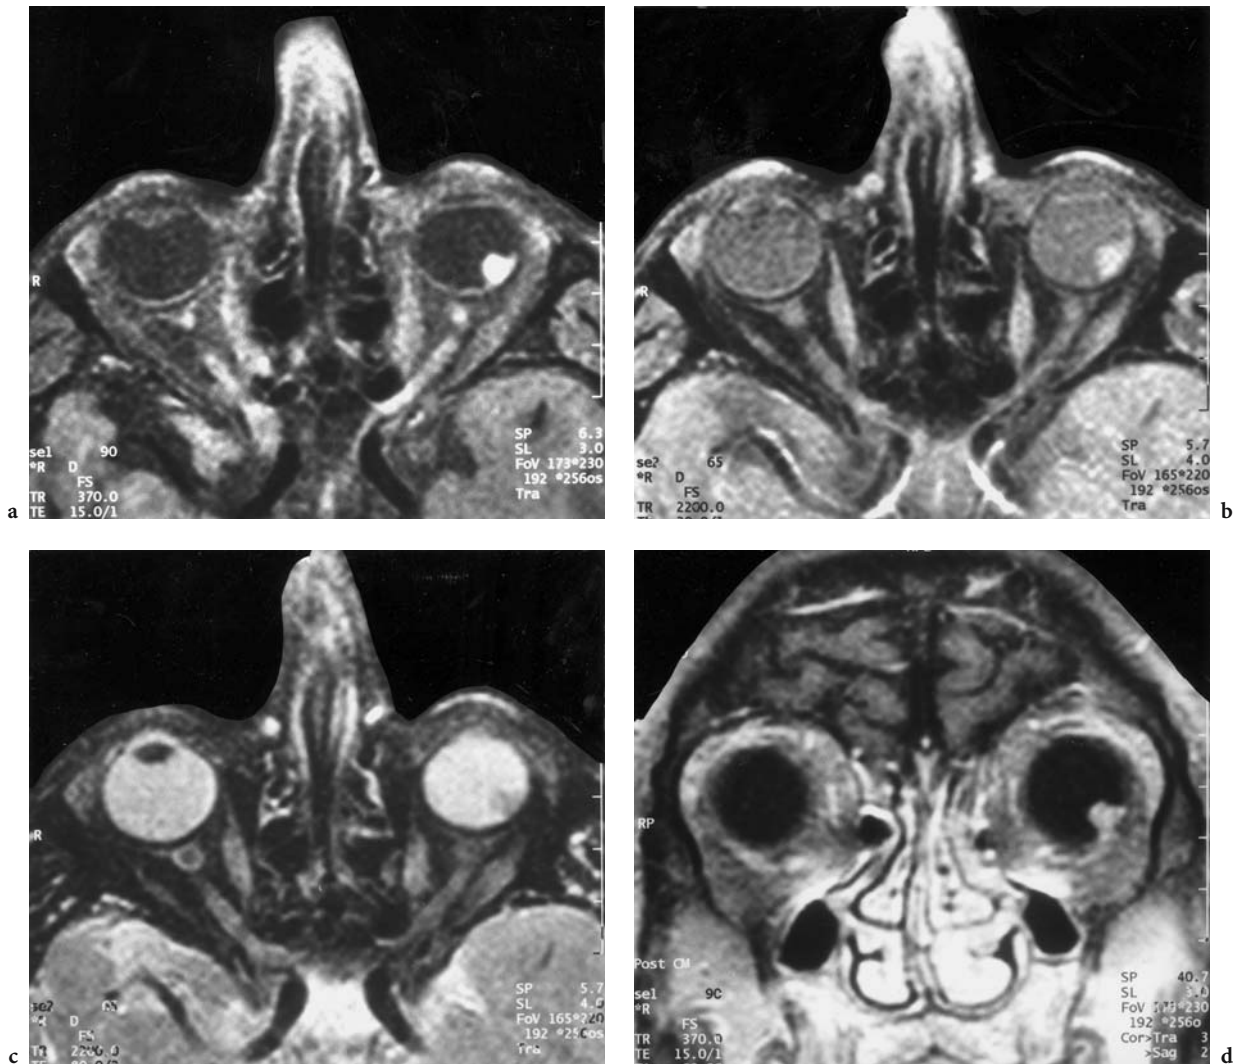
A 73-year-old man with visual deficit of the left eye. Diagnosis: small choroidal melanoma. MRI: a Axial T1-weighted, contrast-enhanced (FS) image showing the small, irregular, but extensive choroidal tumor, located lateral to the macula. b Corresponding proton density image with hyperintense melanin signal. c Corresponding T2-weighted image with signal change to hypointensity. d Coronal T1-weighted, contrast-enhanced view
